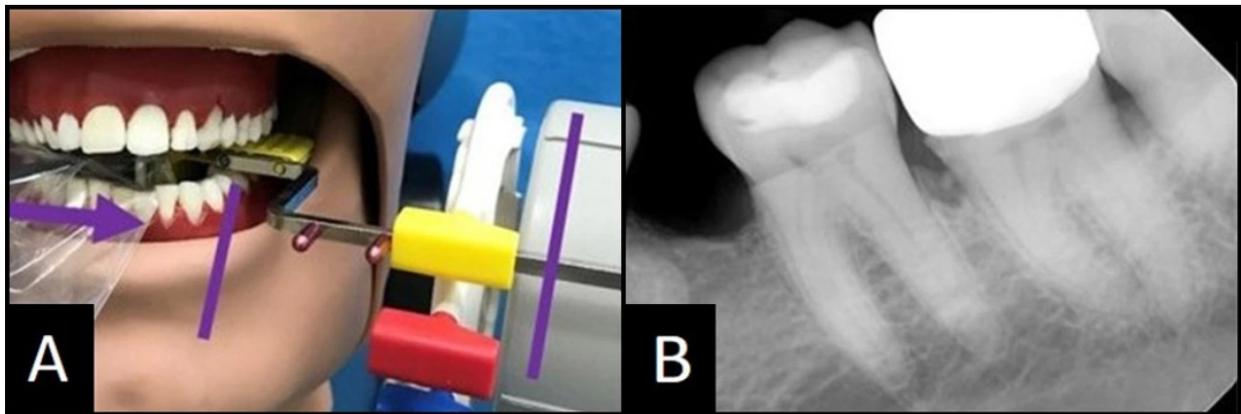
Mandibular Molar Periapical: Ideal
